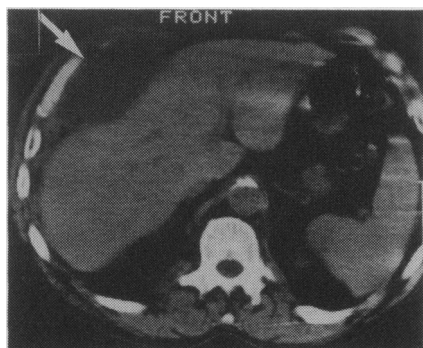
CT scan through the upper abdomen showing a subcutaneous abscess in front of the liver.
